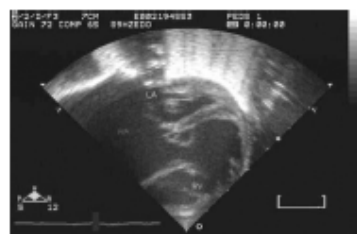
Echocardiogram of a patient with an anacardiably small left ventricle. (LA = left atrium; RA = right atrium; RV = right ventricle.)
